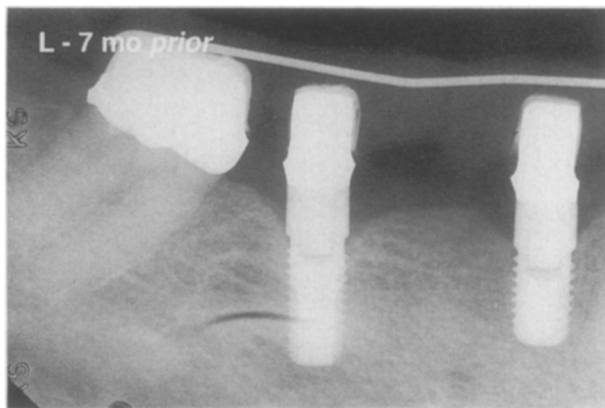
Radiograph shows relationship of gingival margins of molar coping and coping on distal implant fixture. Relationship between mesial gingival margin of coping for molar and alveolar crest is notable.
